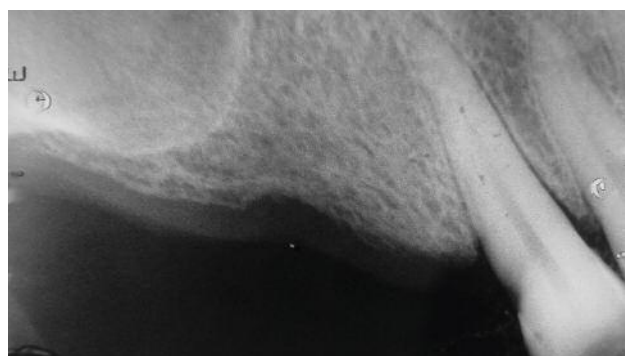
Pre-op X-ray (day 0).
